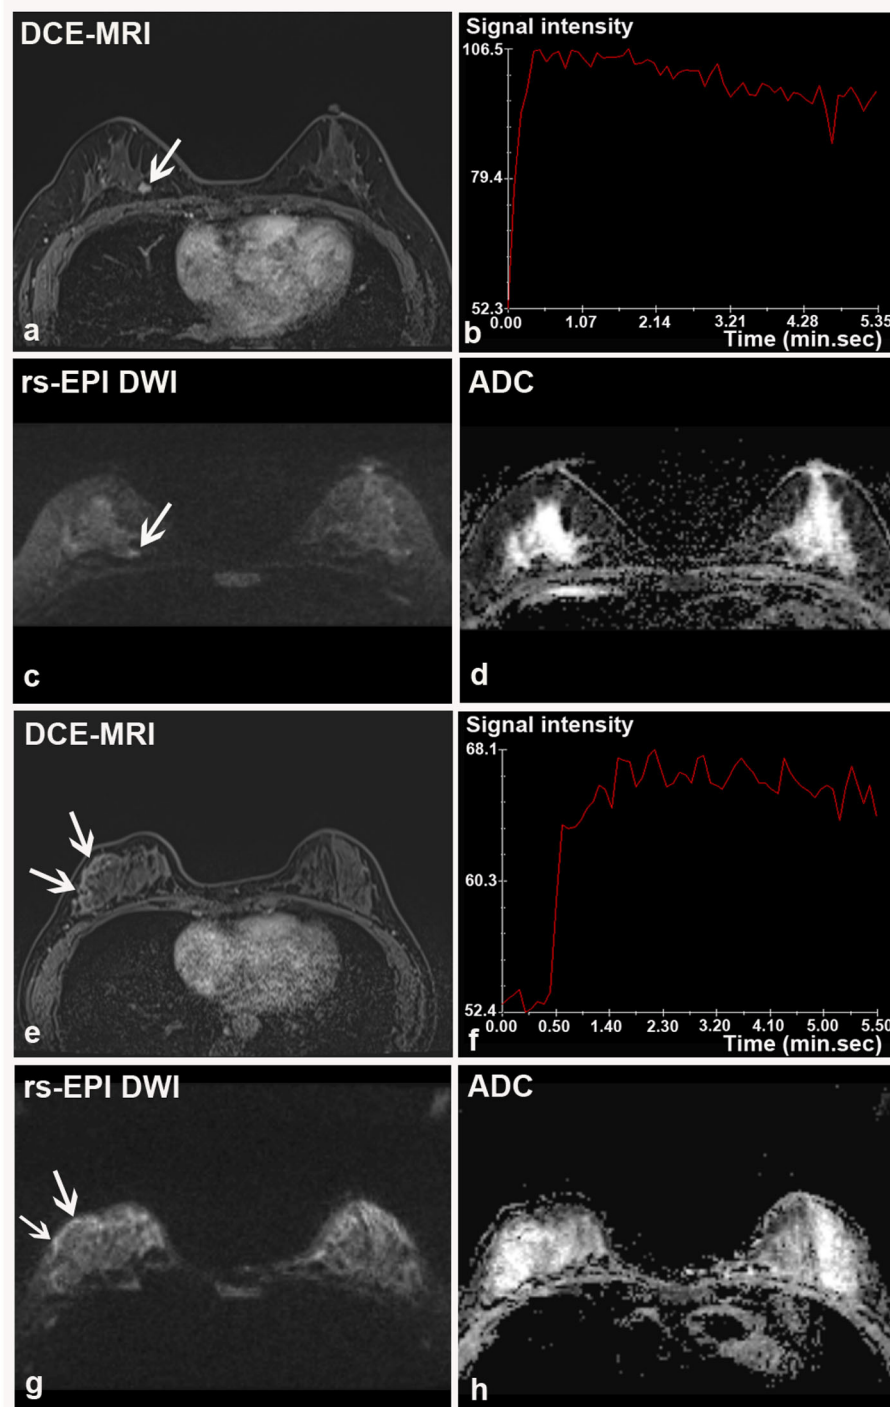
Two breast malignancies missed by rs-EPI DWI in two patients. (a–d) DCE-MRI, time-signal intensity curve (TIC), rs-EPI DWI (b -value, $1,000 \text{ s/mm}^2$), and ADC map of a 55-year-old woman with the right breast ductal carcinoma *in situ*. (a) DCE-MRI shows a lobulated and spiculated nodule (8.7 mm) (arrow) with initial fast enhancement followed by a washout (b) classified as BI-RADS 4. No lesion was found on corresponding rs-EPI DWI (c) and ADC map (d). (e–h) DCE-MRI, TIC, rs-EPI DWI (b -value, $1,000 \text{ s/mm}^2$), and ADC map of a 42-year-old woman with the right breast ductal carcinoma *in situ*. (e) DCE-MRI shows non-mass-like enhancement along the parenchyma surface (arrow) with initial fast enhancement followed by plateau (f) classified as BI-RADS 4. No lesion can be identified on corresponding rs-EPI DWI (g) and ADC map (h). Slight high signal can be retrospectively observed for both cases on rs-EPI DWI (c,g), respectively (arrow), but it was not considered sufficient to confirm the presence of lesions. The latter finding may be attributable to the inferior spatial resolution (5 mm) of our rs-EPI DWI protocol relative to DCE-MRI protocol.
